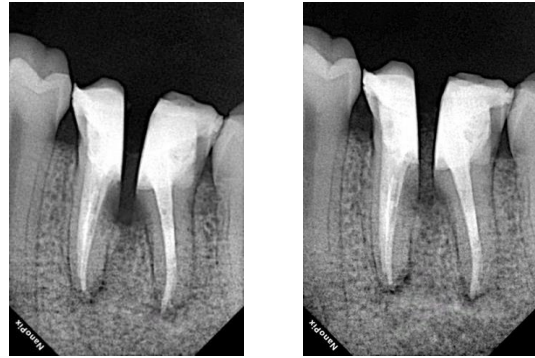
A radiographic examination was conducted prior to and one month post hemisection and bone graft surgery.
